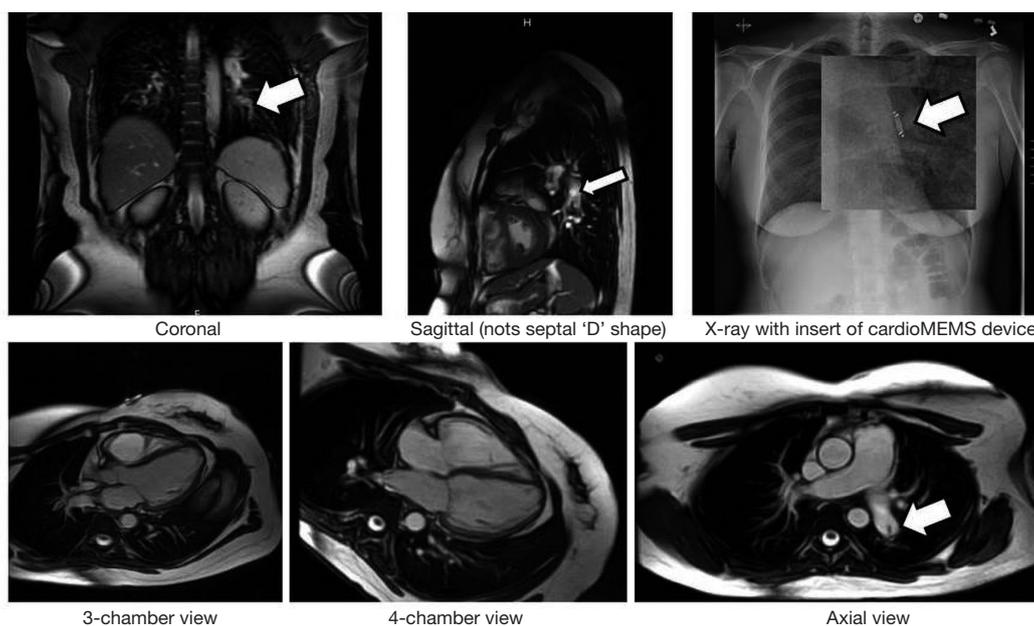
Panel of five cardiac MRI images in the vicinity of the CardioMEMS device obtained using phased-array coils show no evidence of artifact or distortion due to the device (location indicated by arrow). X-ray shows location of implanted device.
